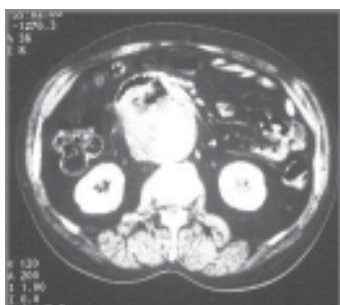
CT scan showing gas in the aneurysmal aorta in a patient with history of melena suggestive of primary Aorto-enteric fistula
